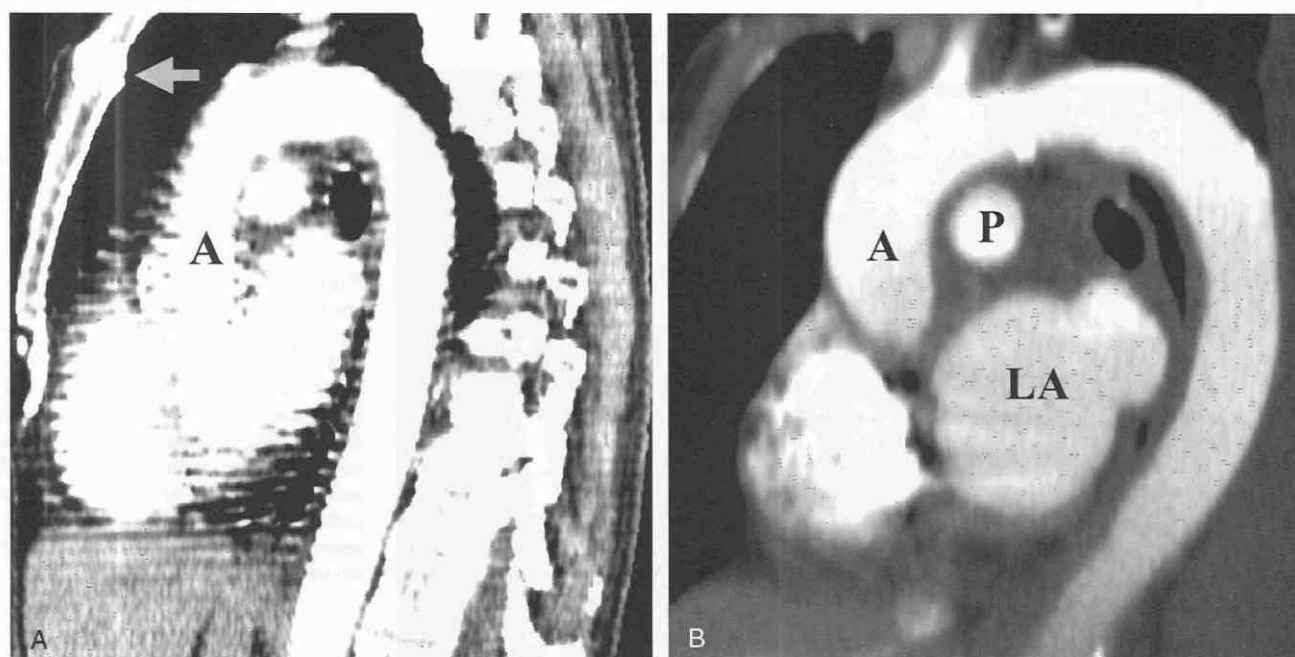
A, Sagittal multiplanar reconstruction (MPR) CT scan of the thoracic aorta. Arrow denotes the position of the sternum. Note the prominent cardiac pulsations with this conventional single-slice CT scan. B, Sagittal MPR CT scan of the thoracic aorta obtained with a multislice CT scanner. Note the lack of reconstruction artifacts in comparison with A. A = aorta; LA = left atrium; P = pulmonary artery.
